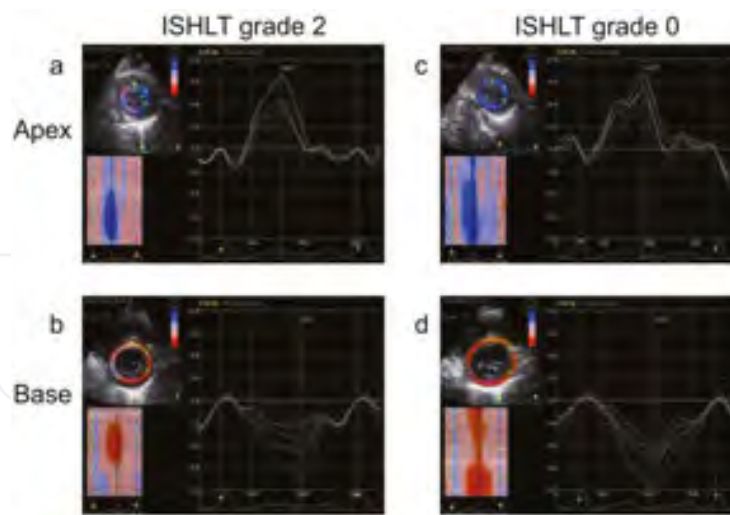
Representative 2D speckle-tracking echocardiogram and analysis of torsion in a patient with and without rejection. (quoted from Ref. [35]). Representative 2D-STE imaging with rotation curves obtained from the same recipient (a 32-year-old man) at LV short-axis views of the apex (a, c) and the base (b, d). Each color of the deformational curve represents one segment of the LV, and the dashed white curve depicts the mean rotation of six segments. The LV-tor, defined as the difference between apical basal end-systolic rotation when the patient had ISHLT grade 2 rejection, was 10.9 degrees (a, b). The LV torsion accompanied with ISHLT grade 0 after rejection treatment was 15.6 degrees (c, d). The % change of LV torsion in this patient at the time of rejection was approximately 30% decreased from his baseline. ISHLT, International Society for Heart and Lung Transplantation; LV, left ventricular; 2D-STE, 2D speckle-tracking echocardiography; EMB, endomyocardial biopsies; HTx, heart transplant recipients.
